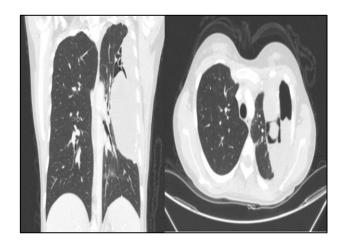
Enhanced computed tomography scans of left lung with a voluminous lesion that occupies the entire lung, multilobulated, heterogeneous with a predominant hypodense density, linear calcifications of the septa with dimensions of 11.2 cm, compressing the main bronchus and segmental lower lobe.
